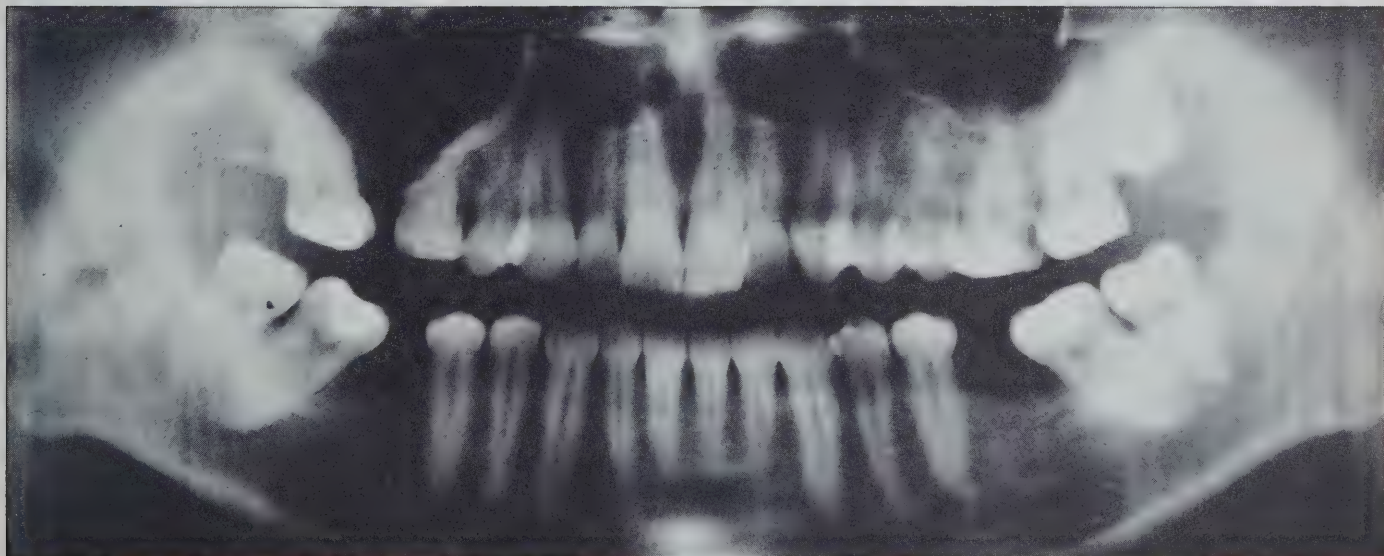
Panoramic radiograph of the lesion in the maxillary right quadrant. Minute calcifications and an unerupted tooth are present.
